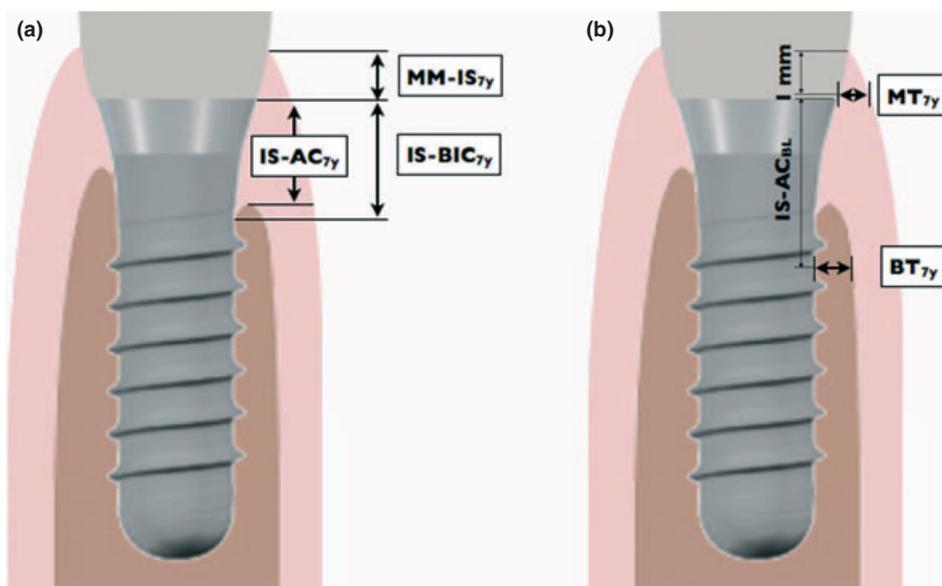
Seven-year follow-up cone beam computed tomography (a) vertical and (b) horizontal measurements of bone and soft-tissue dimensions at the mid-buccal aspect of the implants.
